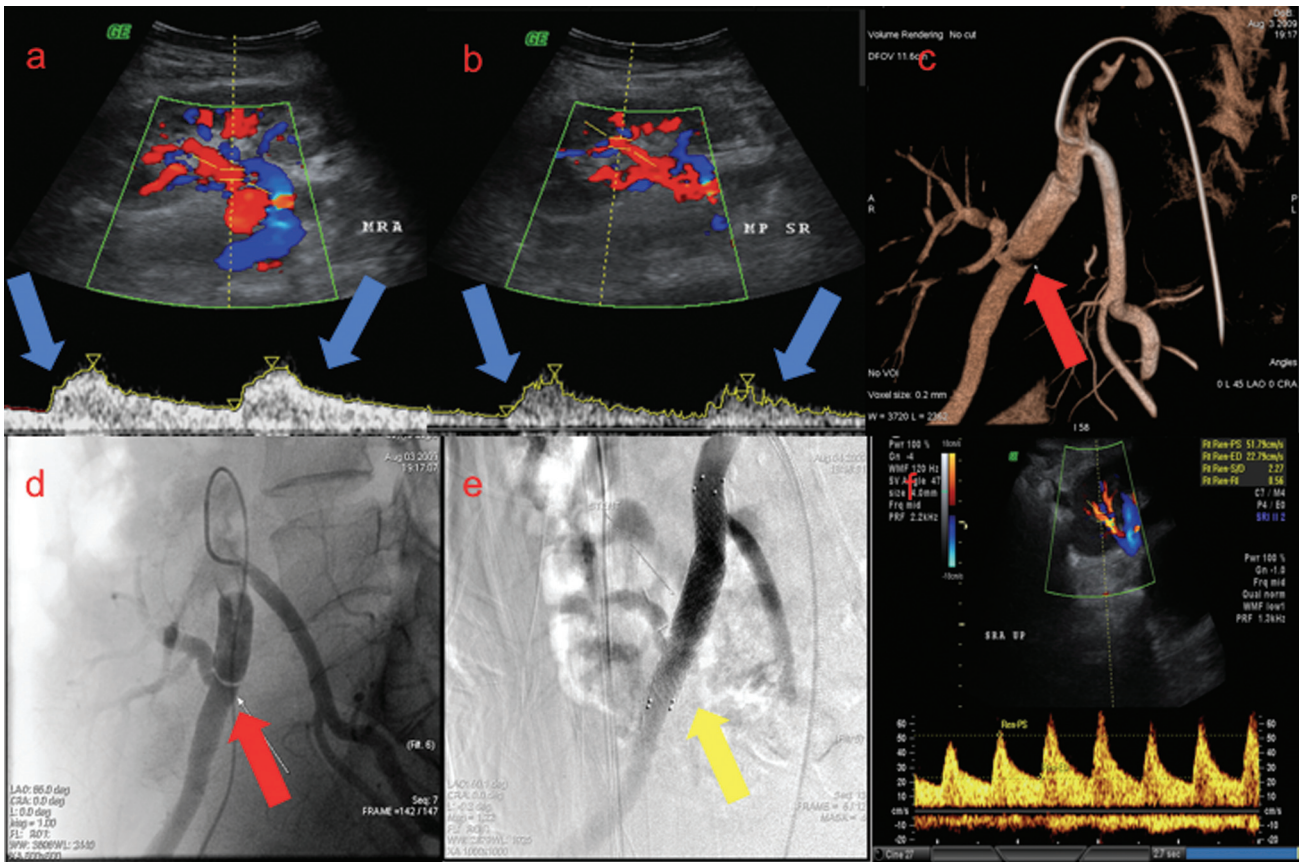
Doppler images (a and b) of a posttransplant patient with worsening renal function show parvus tardus waveform in main and intraparenchymal renal arteries. Virtual reconstructed CT image (c) shows external iliac artery dissection (red arrow) immediately proximal to the renal artery anastomosis. The same finding was demonstrated in DSA of the right external iliac artery (d). The dissection was treated with stenting with a self-expandable bare metal stent (right brace), and poststenting DSA (e) shows recanalized right external iliac artery with filling of the transplant renal artery. Poststenting intraparenchymal arterial spectral doppler image (f) shows a typically normal waveform. CT, computed tomography; DSA, digital subtraction angiography.
